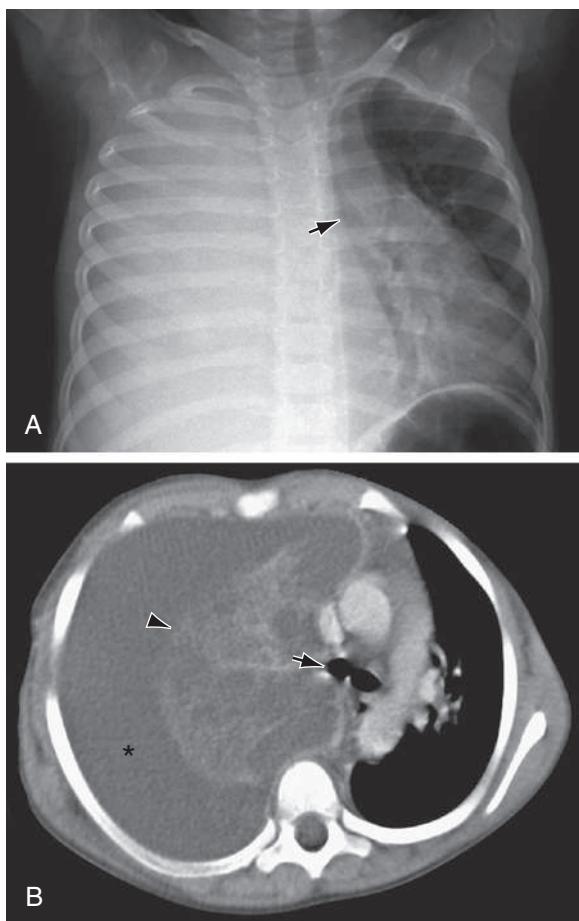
Pneumonia and parapneumonic effusion in a 4-yr-old child. A, Chest radiograph shows complete opacification of the right thorax as a result of a large pleural effusion. Note the shift of the mediastinum and trachea (arrow) to the left. B, Thoracic CT scan shows a large right pleural effusion (asterisk) surrounding and compressing the consolidated right lung (arrowhead). Note the shift of the mediastinum and tracheal carina (arrow) to the left.
